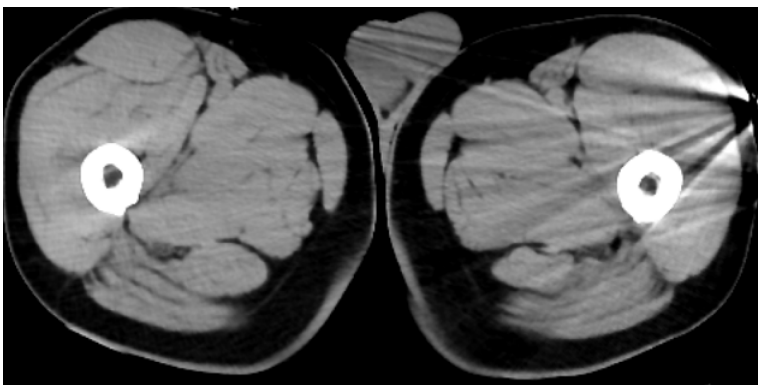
Computed tomography scans of the scrotum. Abnormal findings are not apparent.
